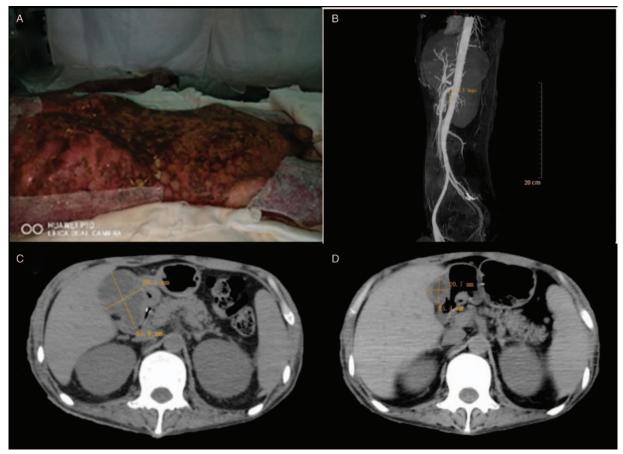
Imaging of the patient and abdominal CT examination. (A) Patient, August 2, 2018. (B) CTA, August 7, 2018. Angle between superior mesenteric artery and abdominal aorta: 46.2°. (C) CTA, August 7, 2018. Duodenum compressed by enlarged gallbladder. (D) CT August 29, 2018. Gall bladder/fluid reduced; pressure on duodenum reduced; duodenal cavity increased. CT: Computed tomography; CTA: Computed tomography angiography.
